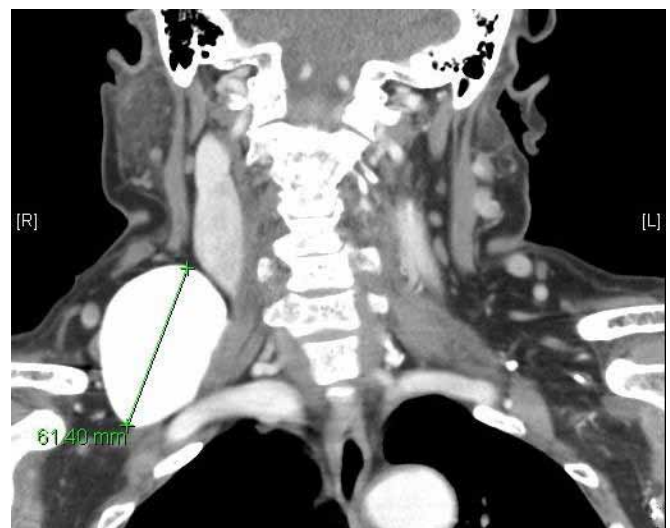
Contrast-enhanced CT image shows a 6-cm aneurysm in the right neck.
